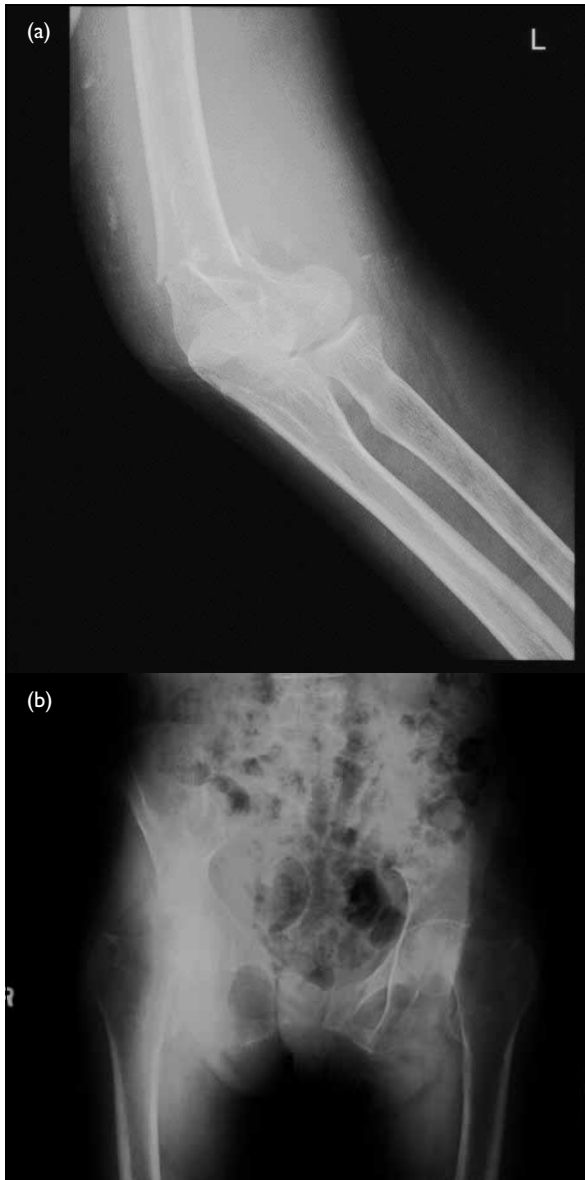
X-rays of case 2 showing the (a) supracondylar fracture and (b) coxa vara
